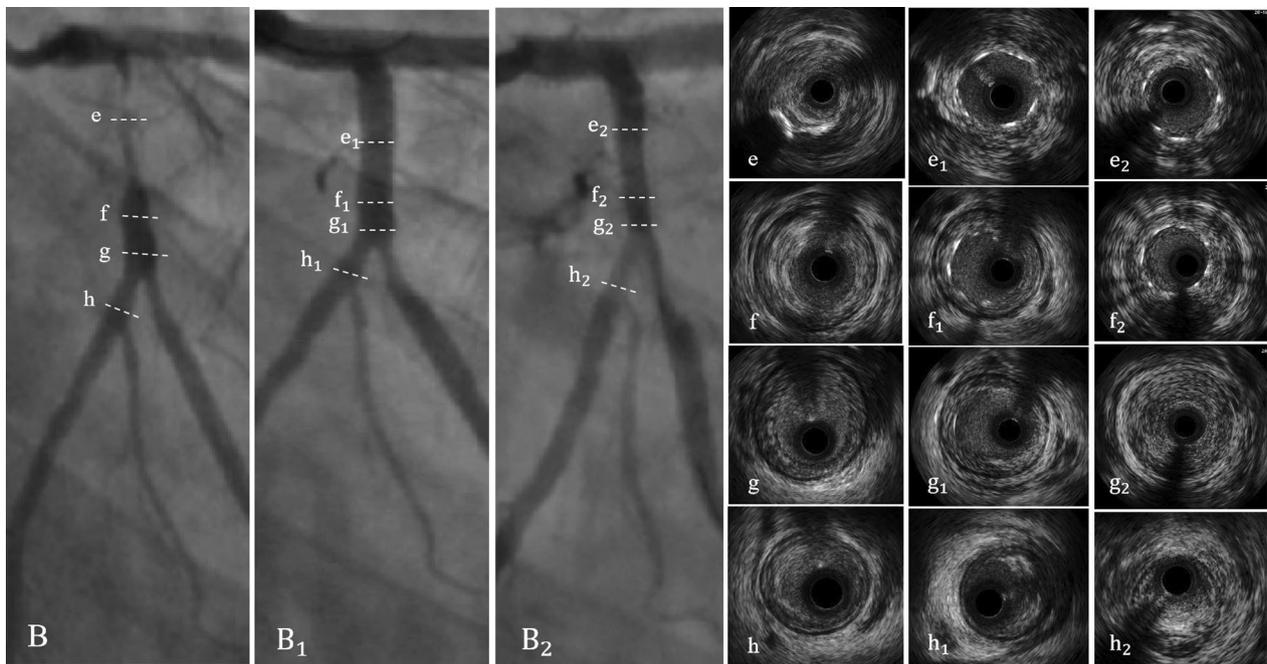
Coronary angiogram and intravascular ultrasound images of the restenotic lesion of left anterior descending artery and left main. A Angiogram of left anterior descending artery before platinum chromium everolimus-eluting stent implantation. a–d Intravascular ultrasound images of left anterior descending artery before the first percutaneous coronary intervention. (A<sub>1</sub>) Angiogram of left anterior descending artery after platinum chromium everolimus-eluting stent implantation. a<sub>1</sub>–d<sub>1</sub> Intravascular ultrasound images of left anterior descending artery after the first percutaneous coronary intervention. (A<sub>2</sub>) Angiogram 6 months after percutaneous coronary intervention showing obvious in-stent restenosis of left anterior descending artery. a<sub>2</sub>–d<sub>2</sub> Intravascular ultrasound images of left anterior descending artery 6 months after first percutaneous coronary intervention showing diffuse low-echoic neointima in the in-stent restenosis lesion, especially in the overlap and opening edge of stent
